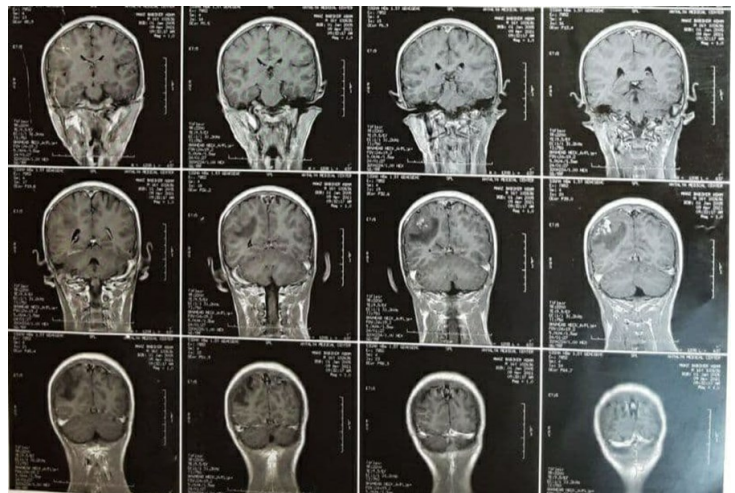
MRI brain T1 with contrast coronal cut of the same lesion.
